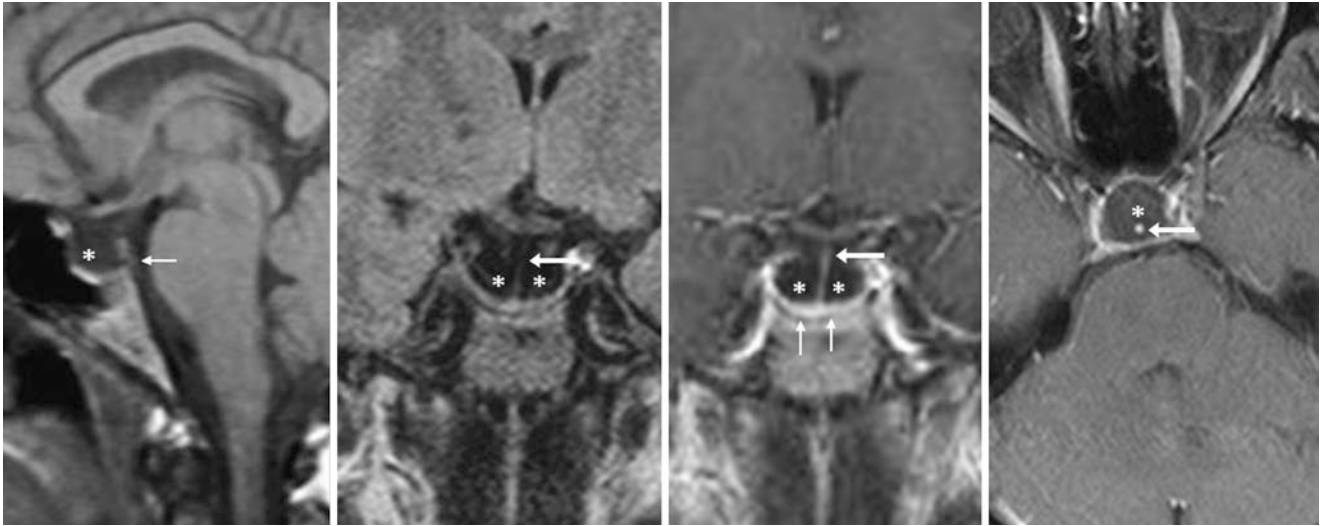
A 46-year-old female patient with seizures and an otherwise negative 1.5 T MRI had a mildly enlarged, partial form of PES (*). Note a normal stalk (arrows) on noncontrast sagittal T1WI (left) and coronal
